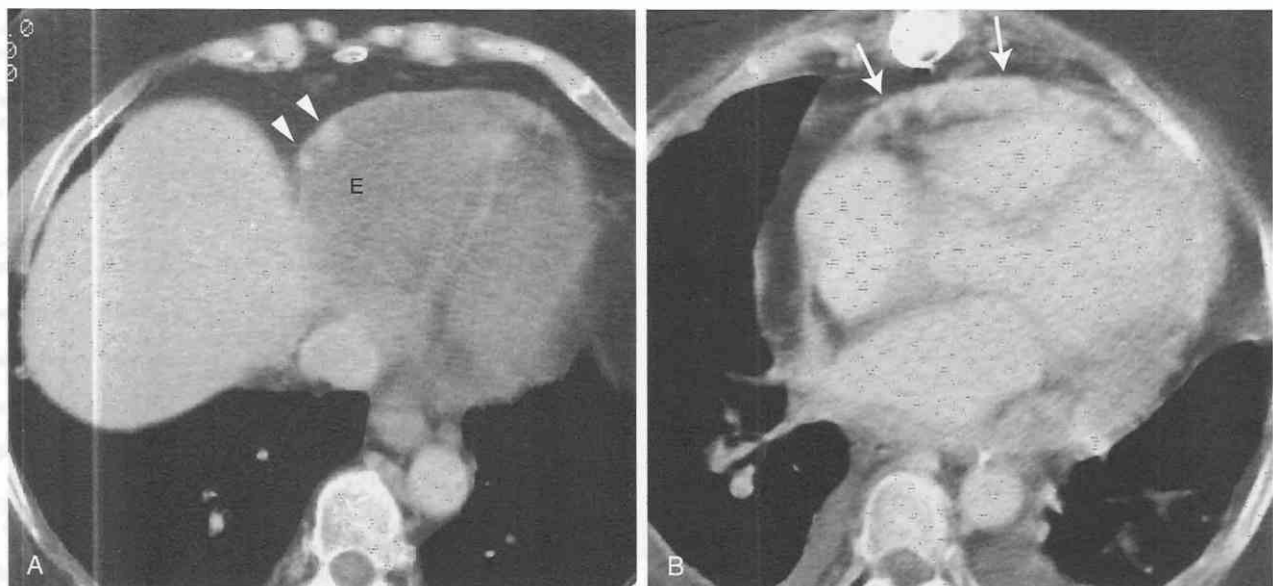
Pericardial metastases from renal cell carcinoma. A, Axial contrast-enhanced CT at a level just inferior to the heart shows a large pericardial effusion (E). Two soft tissue nodules are identified arising from the parietal pericardium (arrowheads). B, Scan performed 6 months later shows filling of the pericardial space with enhancing soft tissue (arrows).
